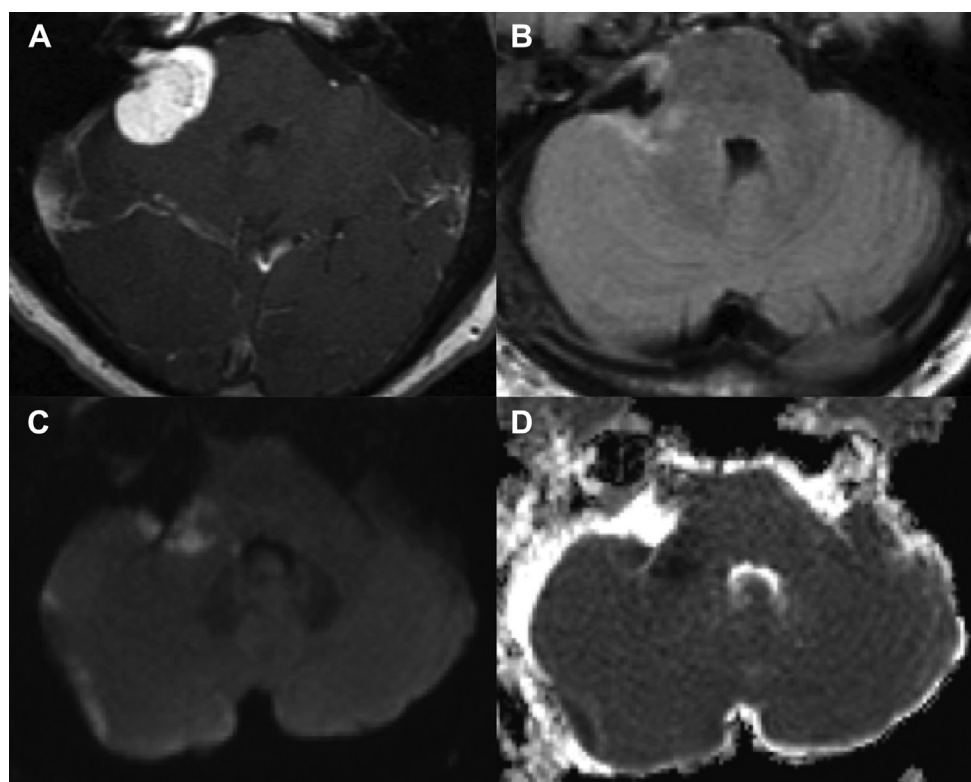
Patient 2. (A) Preoperative T1-weighted post-gadolinium magnetic resonance imaging (MRI) shows cerebellopontine angle mass extending into the right internal acoustic meatus. (B) Following stage 1 tumor debulking, postoperative fluid-attenuated inversion recovery scan demonstrates increasing signal in the right superficial middle cerebellar peduncle
